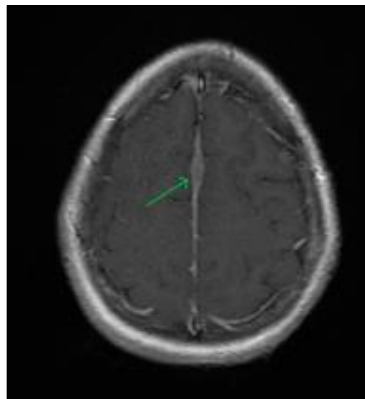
Axial T1+C image of MRI brain at high fronto-parietal region, irregular enhancing thickening along the falx cerebri - characteristic of en-plaque meningioma (green arrow)
